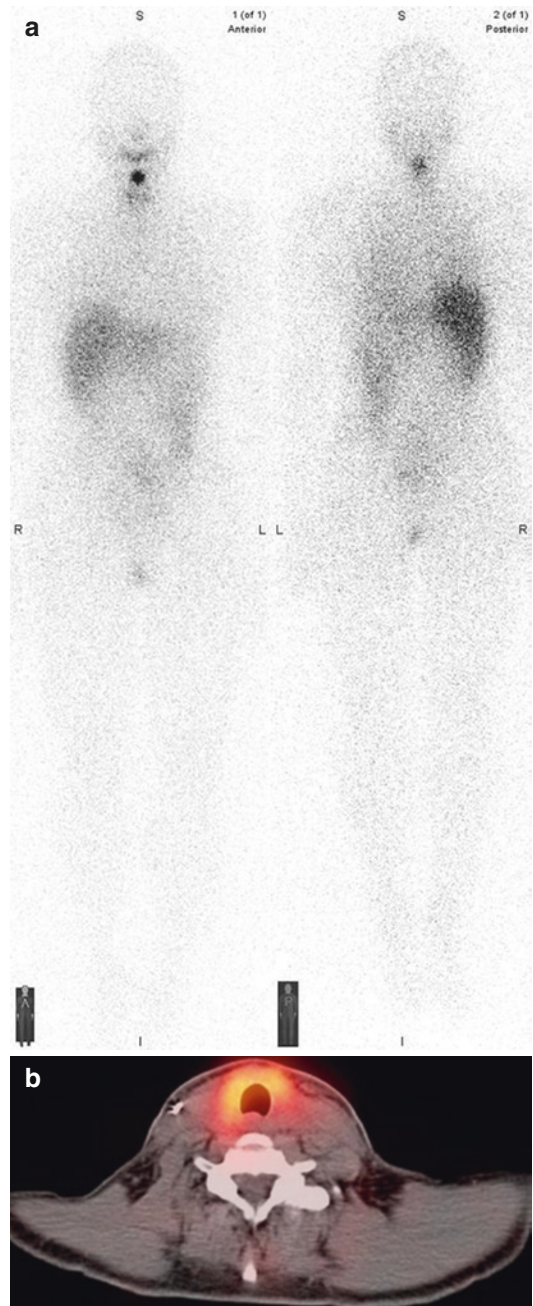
A 40-year-old female with papillary thyroid carcinoma and positive nodal metastases on dissection. TBI (a) with SPECT (b) showing uptake in the neck, which localizes to the thyroid bed. No new metastases were found
